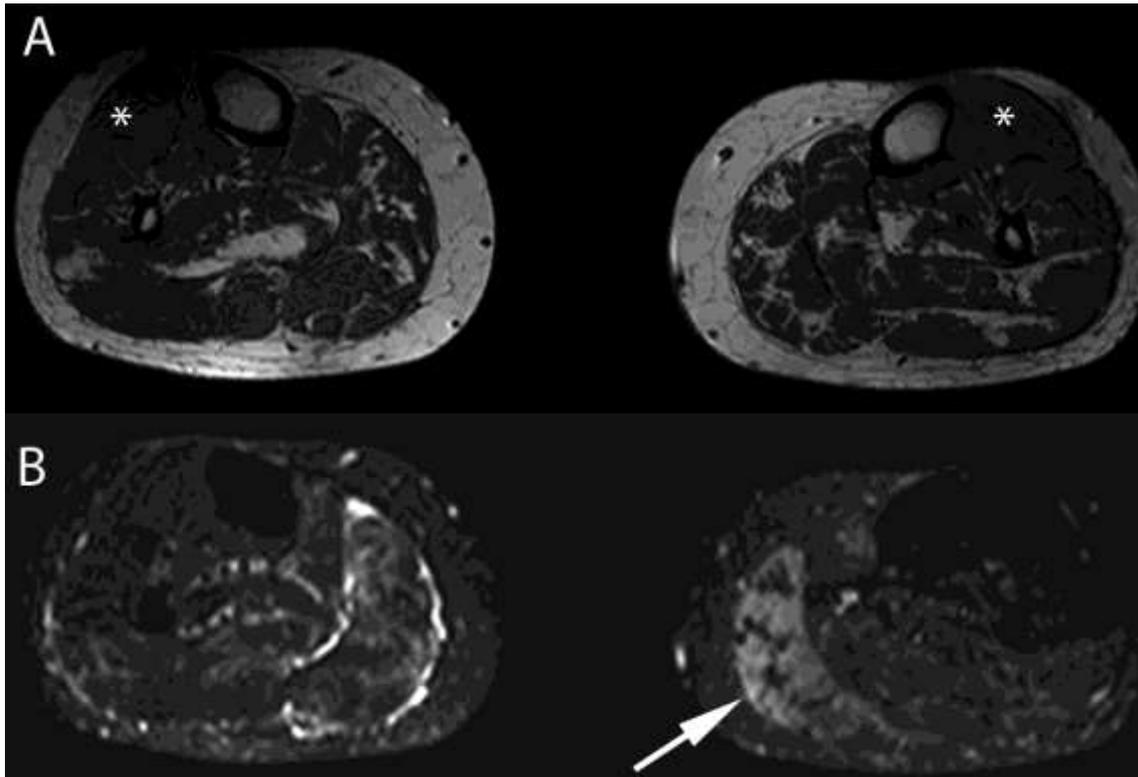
MRI can distinguish between fatty degeneration and muscle edema. Cross sections of both calves of a 44-year-old woman with hypokalemic periodic paralysis (Mutation Cav1.1-R1239H) visualized by 3 Tesla MRT.
